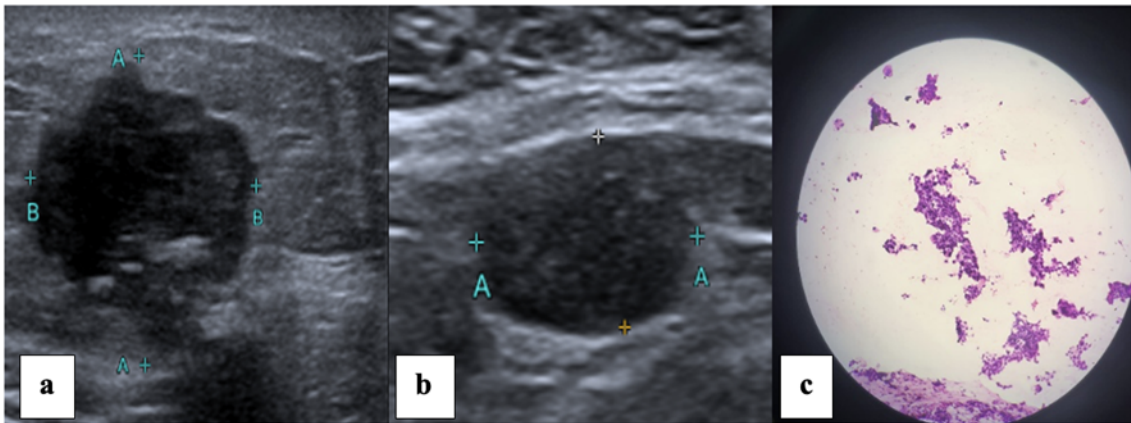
High resolution B mode ultrasound of BI-RADS 5 mass (a), and concentrically thickened lymph node with loss of corticomedullary differentiation (b), with HPE (c) of the metastatic lymph node in a case of HER 2neu enriched molecular subtype of breast cancer
